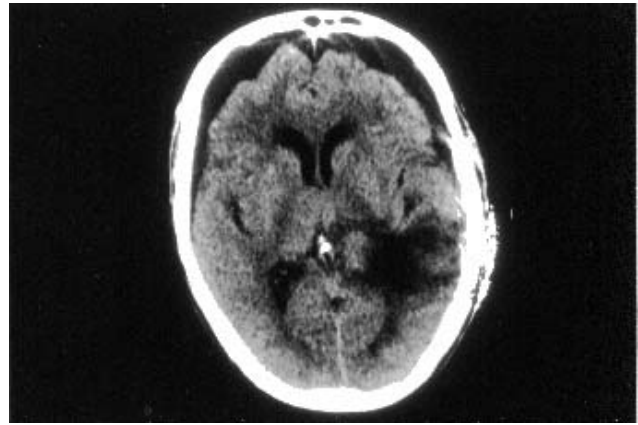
Early postoperative computed tomography scan, demonstrating complete tumor removal and large pneumoencephalus.
